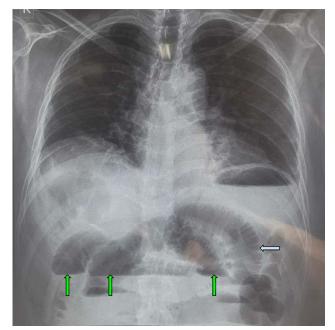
Erect abdominal X-ray showing multiple small bowel air-fluid levels (green arrows) and valvulae conniventes (grey arrow).
